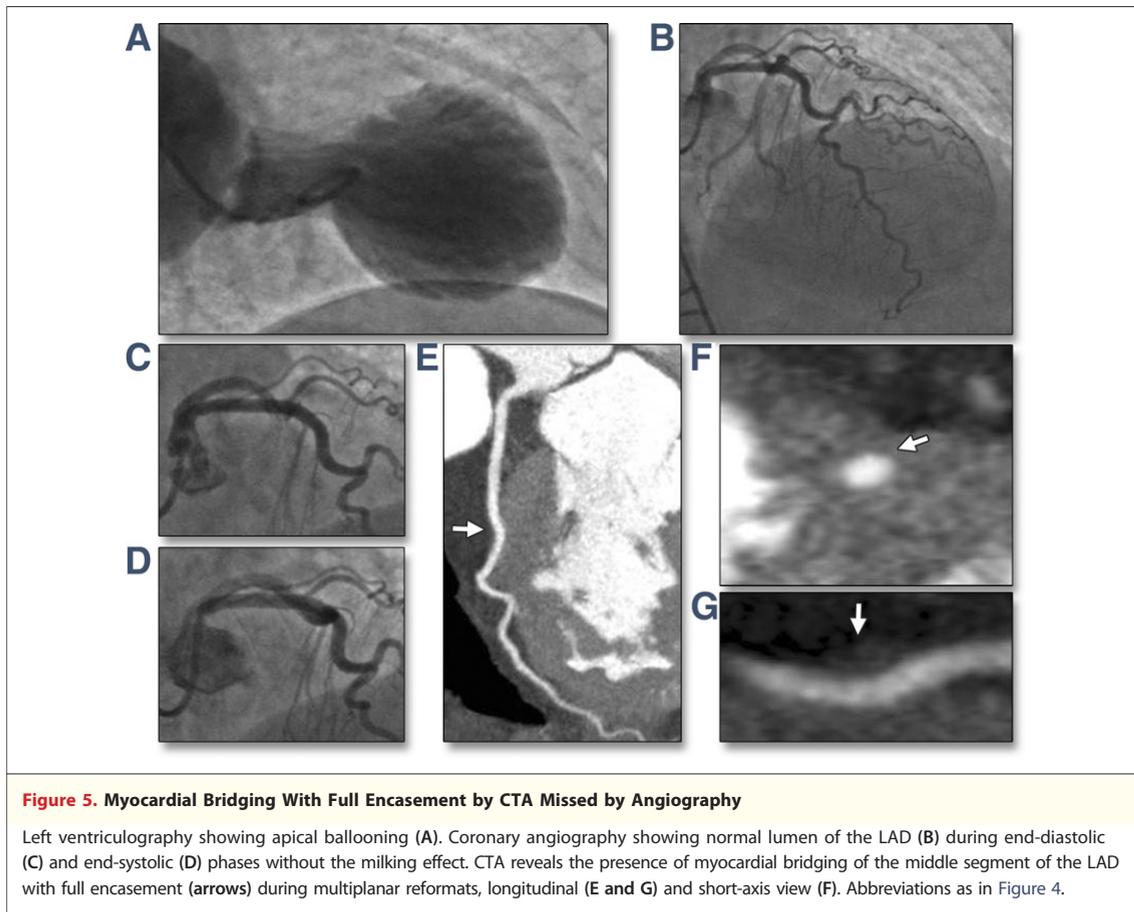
Myocardial Bridging With Full Encasement by CTA Missed by Angiography
